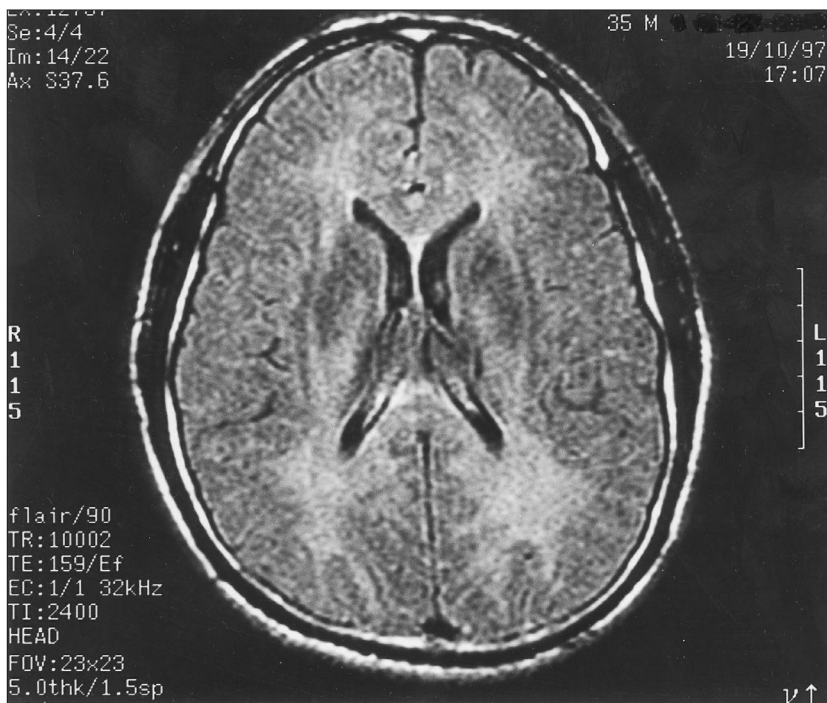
A follow-up fluid attenuation inversion recovery (FLAIR) magnetic resonance image (MRI) of the brain 7 weeks after the first MRI study showing marked reduction in the white matter hyperintensities.
